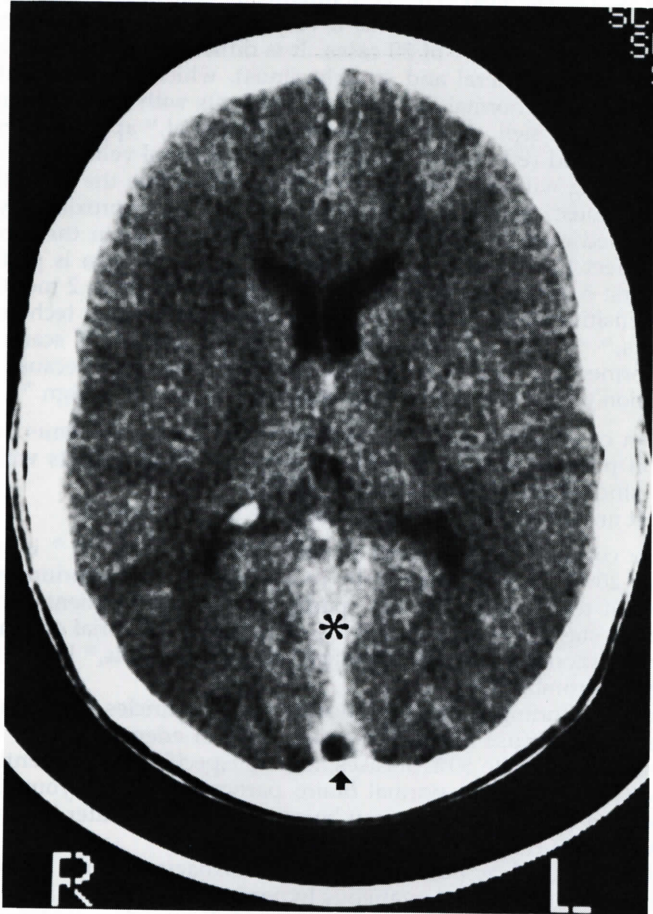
Enhanced CT scan. Empty delta sign indicated by *arrow*. Falx enhancement indicated by *asterisk*.
